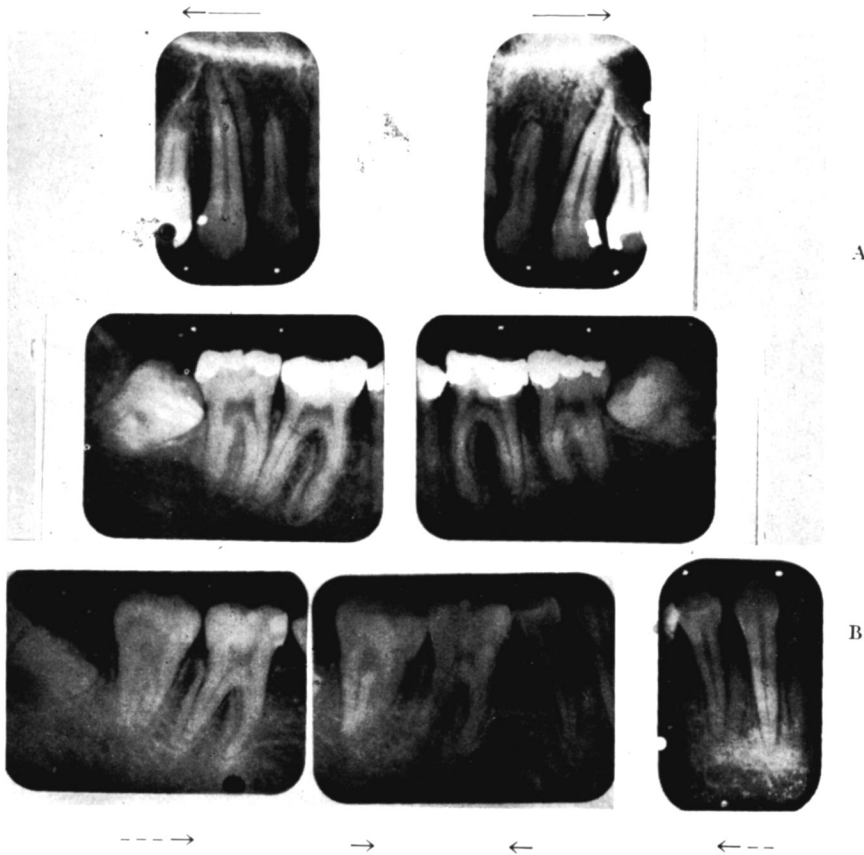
(A) Intra-oral roentgenograms of a patient undergoing orthodontic treatment. The upper cuspids and lateral incisors were moved bodily in a distal direction. Note the very wide lamina dura on the mesial side of the alveolus. The lower first molars were tipped distally and occlusally about a fulcrum near the apex of the distal root. Note how the lamina dura indicates graphically in which direction the tooth is being moved and where bone deposition has occurred. (Arrows indicate direction of tooth movement.)
